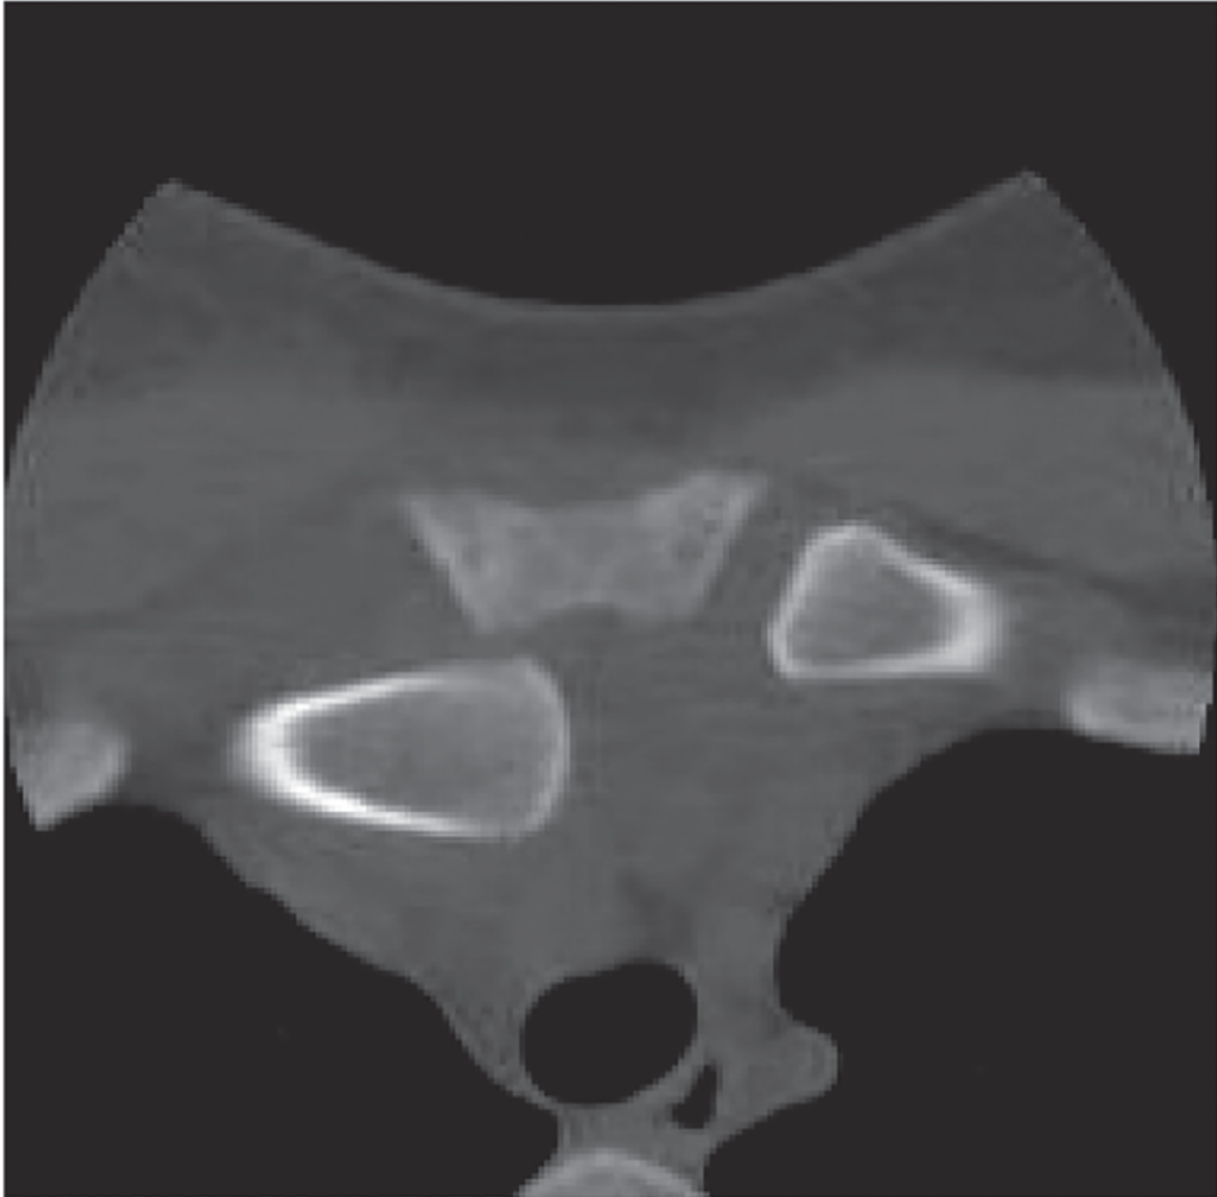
CT axial image of a posteriorly dislocated SC joint. Source: Image adapted from Bontempo and Mazzocca.¹⁰
